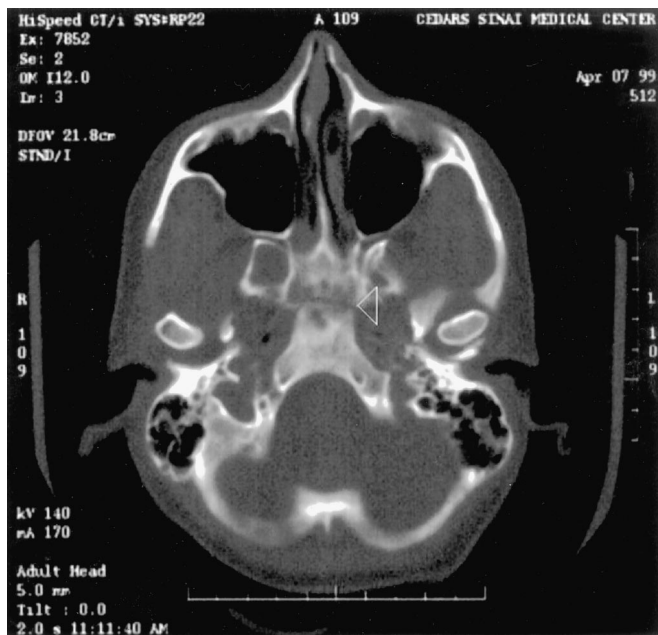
CT scan showing a fracture of the clivus after blunt head trauma. The patient presented with CN III, VI, and VII palsies.
